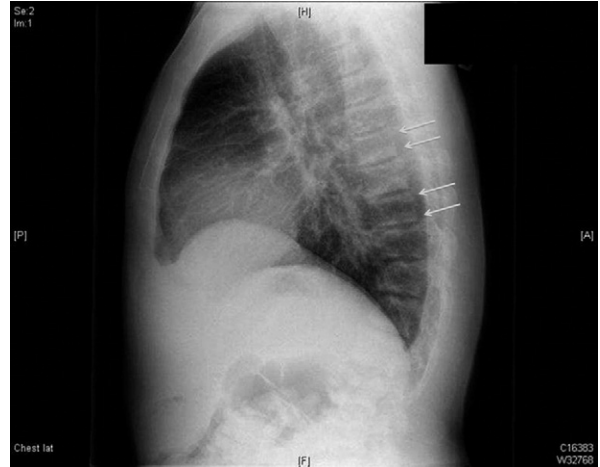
A lateral radiograph of the thoracic spine shows increased opacity (arrows) along the superior and inferior aspects of the vertebral bodies due to osteosclerosis associated with secondary hyperparathyroidism, typical of the “ruger jersey spine.”
